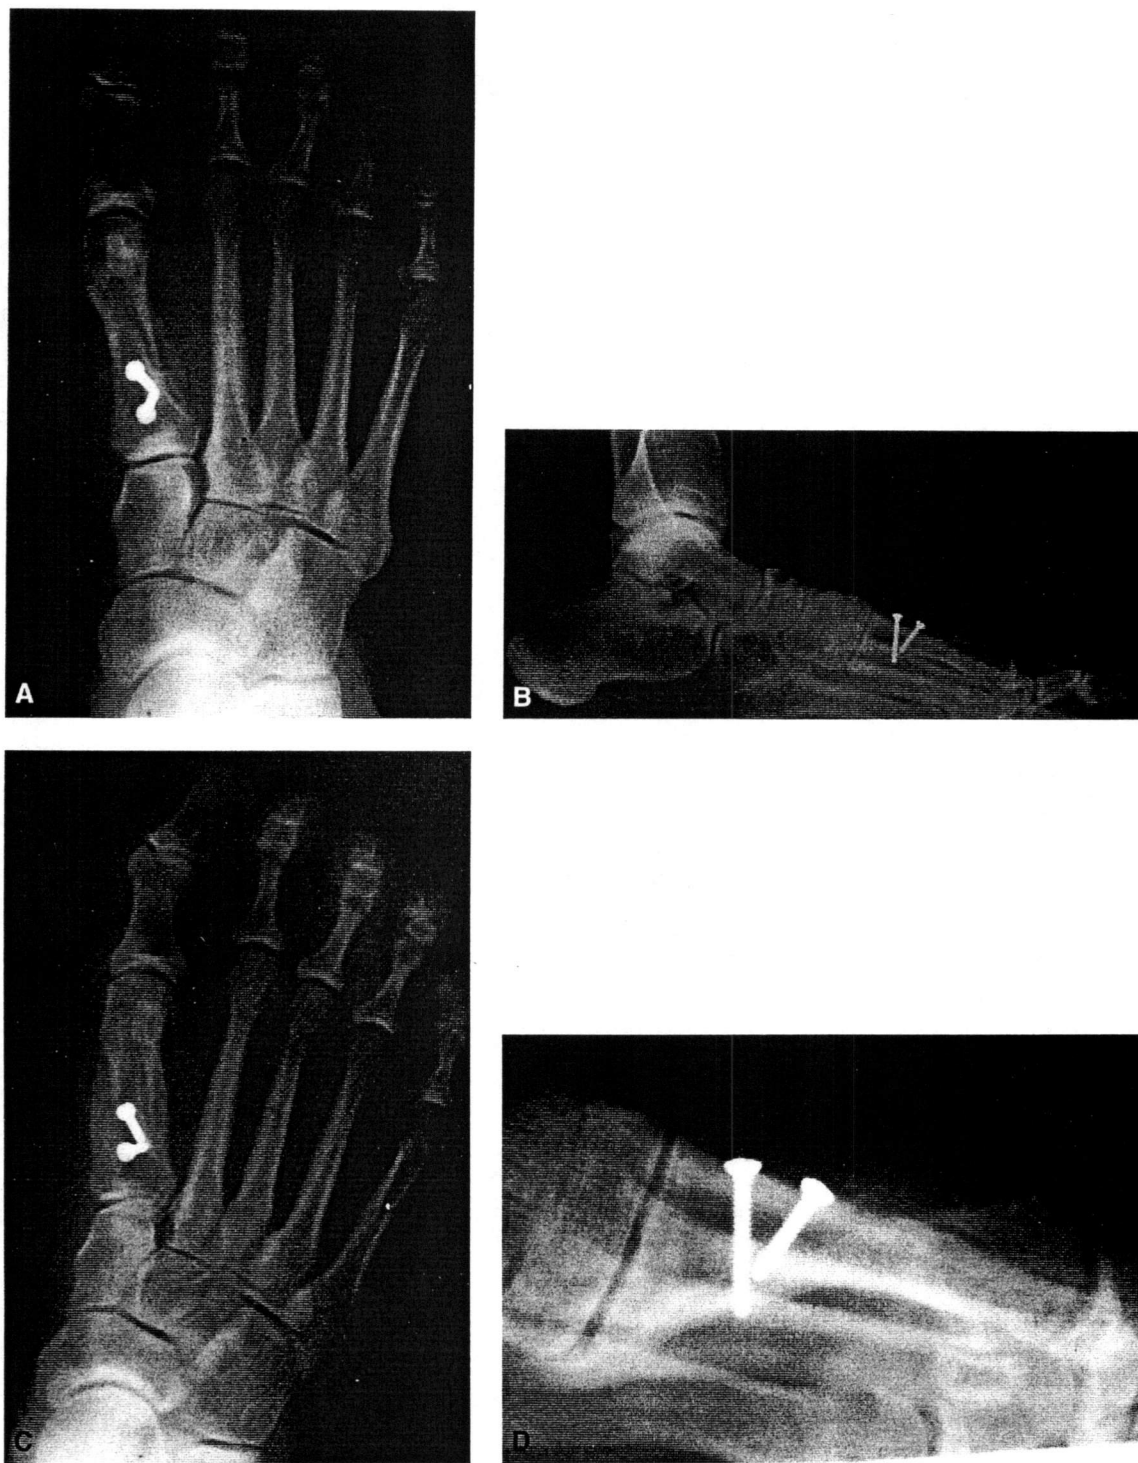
A,B: Dorsal plantar and lateral radiographs, 6 weeks after Mau osteotomy, with the presence of a dorsal shelf fracture resulting from ground reaction forces. C,D: At 10 months postoperatively, note the complete healing and dorsiflexion of the capital fragment.
